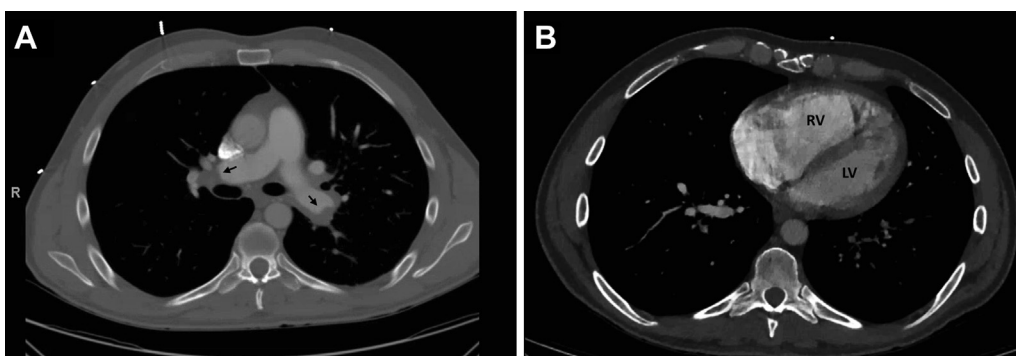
A computed tomography (CT) angiogram showing (A) thrombus in the right and left pulmonary arteries and (B) significant dilation of the right ventricle (RV) with an increased RV/LV ratio. LV, Left ventricle.
